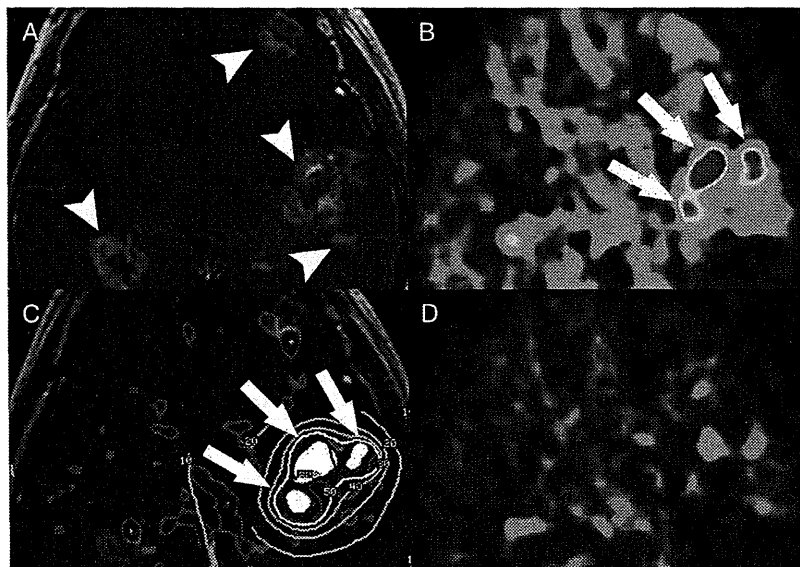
Representative plan for GK surgery for locally recurring brain metastases with guidance from MET-PET/MRI fusion imaging. The patient was a 42-year-old woman with brain metastases from breast cancer who had received 4 previous treatments with GK. A big discrepancy was clearly seen between the area with Gd contrast enhancement on the T1-weighted MR image (A, indicated by arrowheads) and the area with elevated MET uptake (B, indicated by arrows). C, The PET-MRI fusion image was rendered after constructing a binary image (shown in white) indicating areas with MET uptake 1.4 times higher than that in the contralateral brain.^{15,16} D, The GK strategy was to administer a higher radiation dose to areas with higher MET uptake. ¹¹C methionine uptake was markedly reduced in a MET-PET image obtained 6 months after the GK (ie, good control of active cancer).
